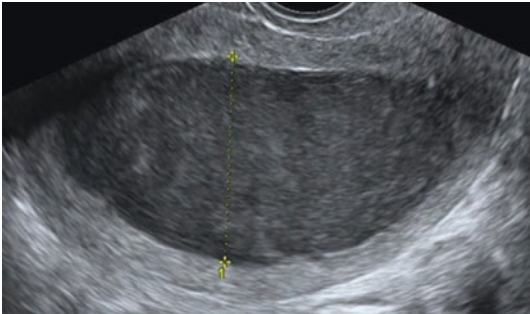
Sagittal section of the uterus on gray-scale (left) and with color Doppler (right): while, on gray-scale, the hypoechoic area could be misinterpreted as a
